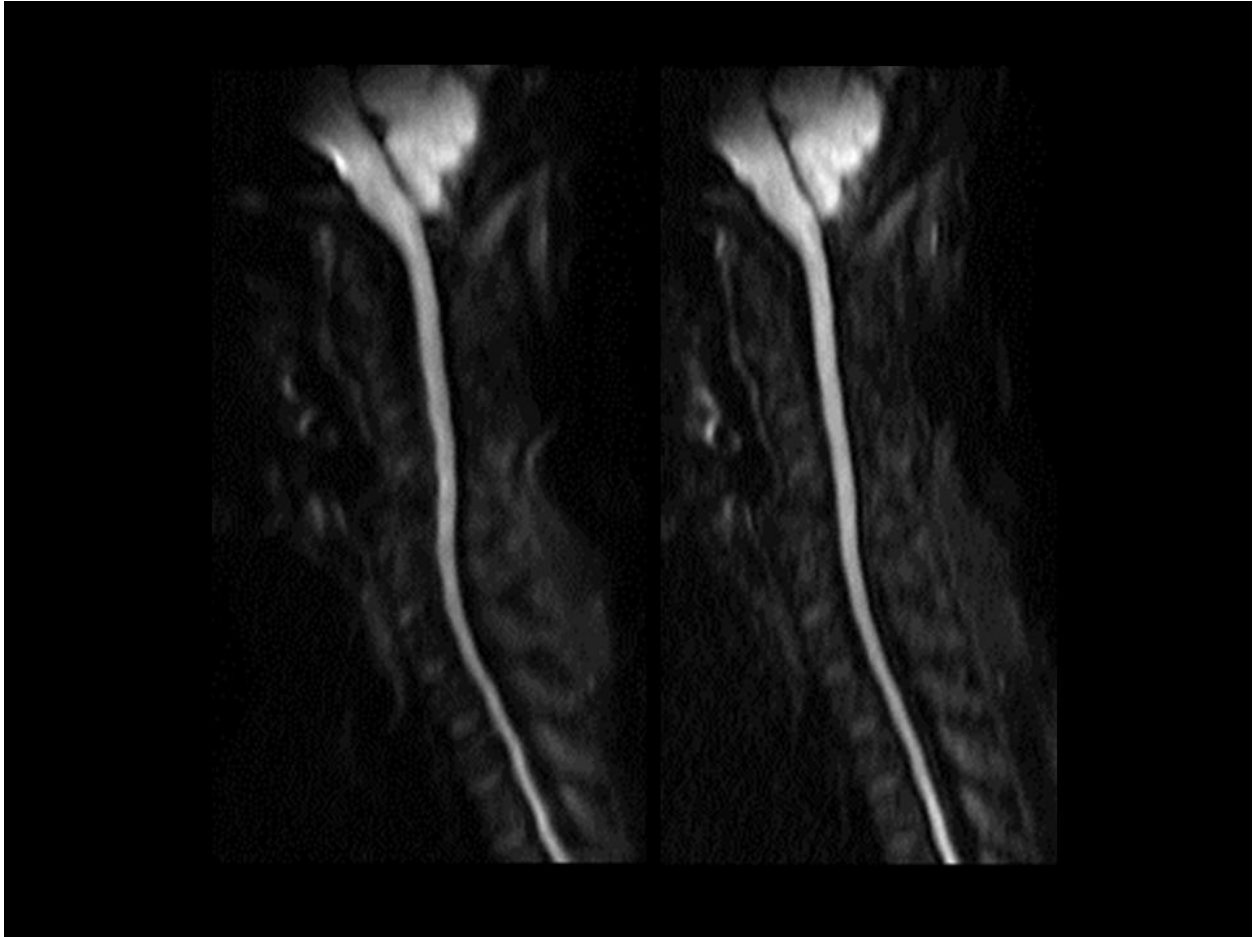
Parallel imaging (PI) in spine DWI. Note the improvement in accuracy of anatomical depiction of the spinal cord with reduced distortion using a PI factor of 2 (left) when compared to the image obtained without PI. Both images obtained with a 3 in 1 DWI technique.
